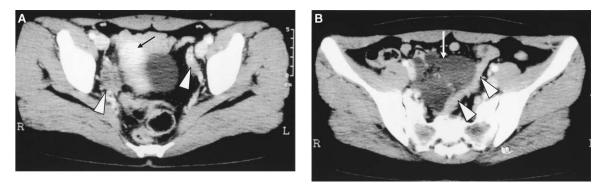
Contrast-enhanced CT scans. A, The cystic mass is adjacent to the uterus (*arrow*), and bilateral ovaries (*white arrow heads*) are evident in the adnexal region separated from the cyst. B, The multilocular cyst (*white arrow*) is adjacent to the small intestine (*white arrow heads*).
